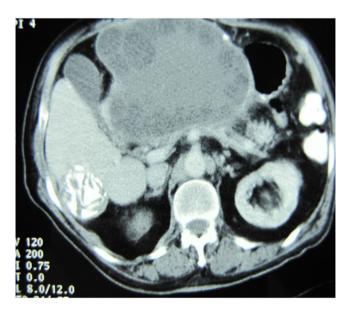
CT showing the huge cyst (20 cm) with the characteristic daughter cysts and clearly delineated reactive layer (pericystic wall) in the second case.
